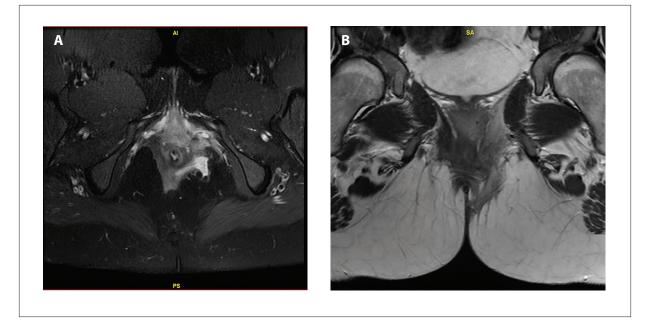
Pelvic magnetic resonance imaging of the patient with Crohn's disease demonstrating a complex, transsphincteric fistula. The fistula tract is shown (A) first coursing horizontally and cephalad traversing the upper left external anal sphincter and (B) then inferiorly through the ischioanal fat to exit at the left gluteal skin.
